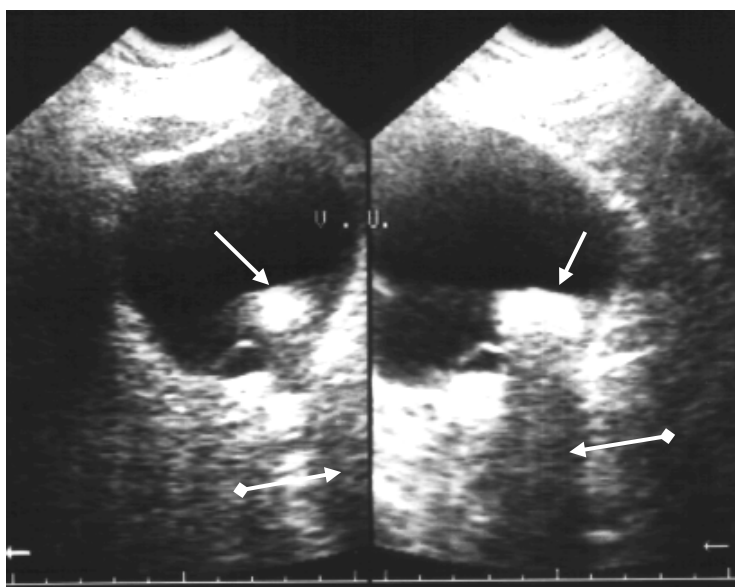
Sonograms of the bladder. A stone in the bladder as hyperechoic area is defined (arrows). Hypoechoic acoustic shadow (arrows with rhombus).
